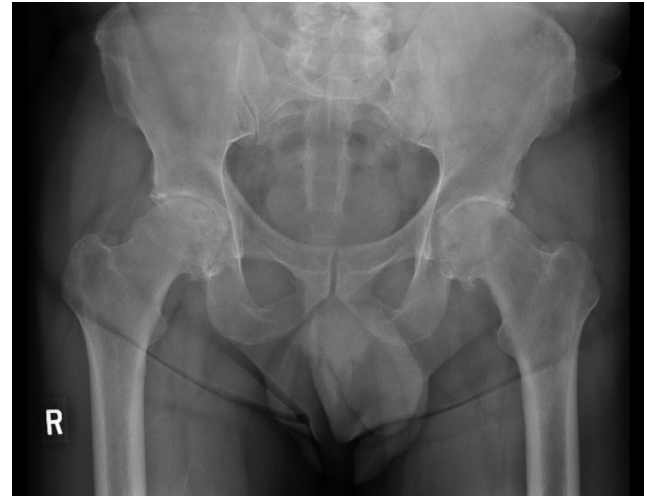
Case 3 preoperative antero-posterior pelvis radiograph demonstrating bilateral hip osteoarthritis.
